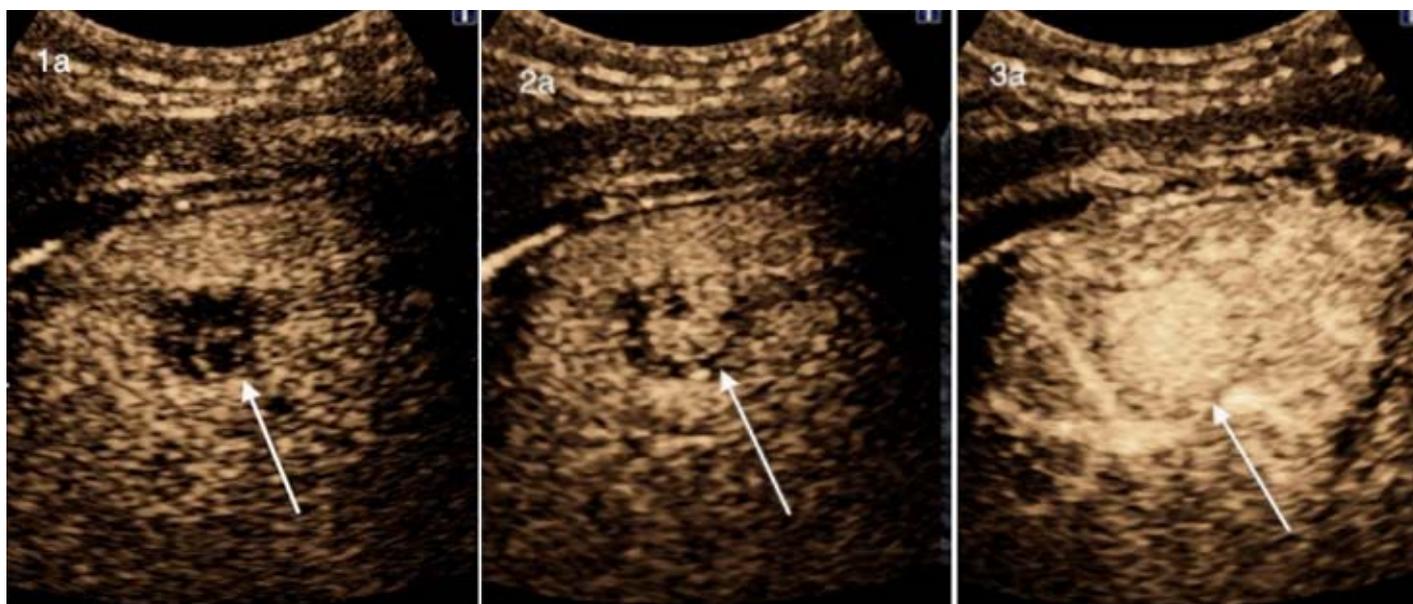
Sequential contrast enhanced ultrasound images acquired at 7 (left), 12 (centre), and 20 (right) seconds after contrast injection. They show intense initial central and subsequent radial enhancement (arrows) consistent with focal nodular hyperplasia
